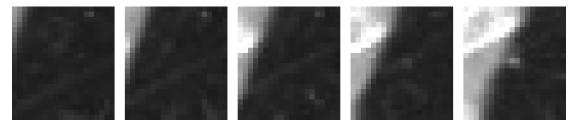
Enlargements of the same area of coronal CT section images 75 to 79 where the final frame shows the identified structure.
